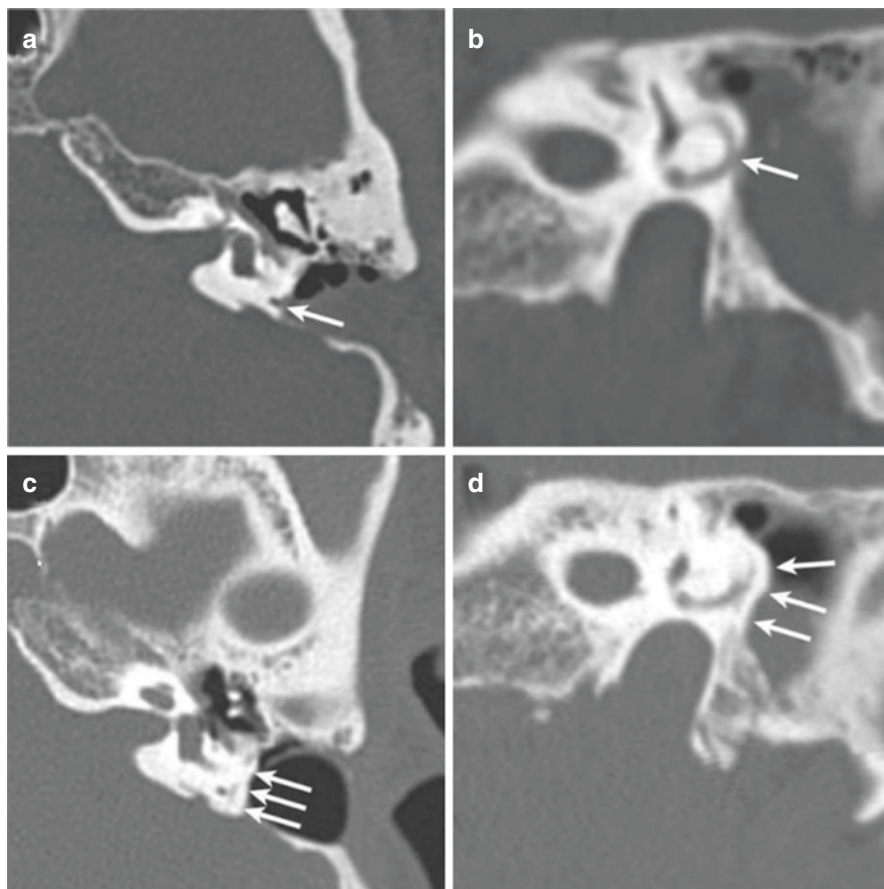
Computed tomographic scan of right temporal bone demonstrating dehiscence of the posterior semicircular canal in axial (a) and coronal view (b) following endolymphatic sac surgery, with arrows pointing to site of dehiscence. Scans demonstrating subsequent repair with arrows pointing to hydroxyapatite resurfacing in axial (c) and coronal view (d). (Adapted with permission from Bartholomew et al., 2019 [27])
